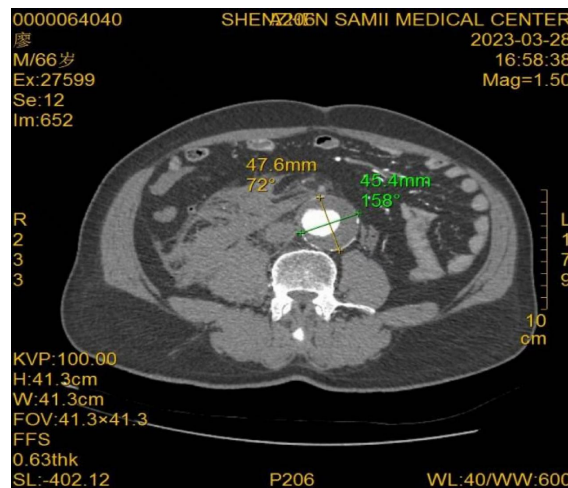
Computed tomography angiography (CTA) shows ruptured abdominal aortic aneurysm (AAA). Transverse diameter (major axis) = 47.6mm of AAA; vertical diameter (minor axis) = 45.5mm of AAA.
